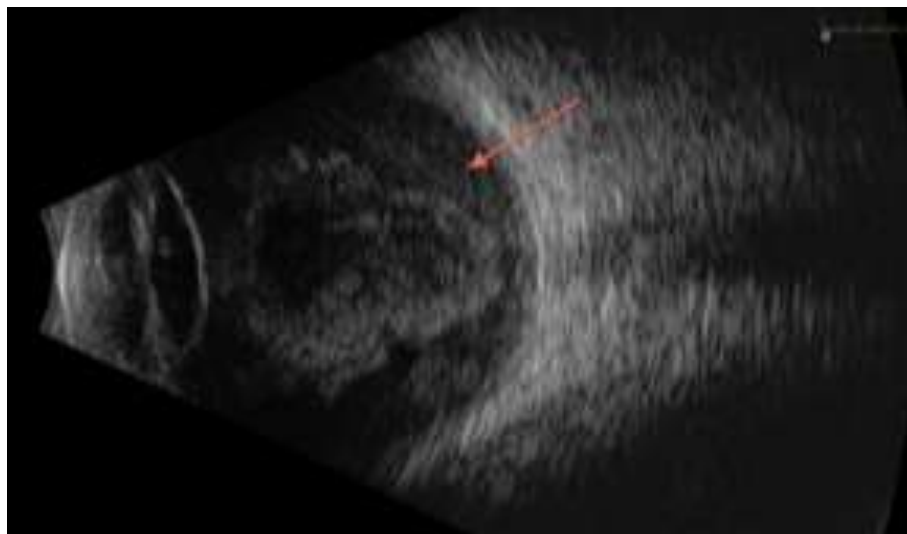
B-scan ultrasonography demonstrating significant vitreous debris in an eye with acute endophthalmitis.
